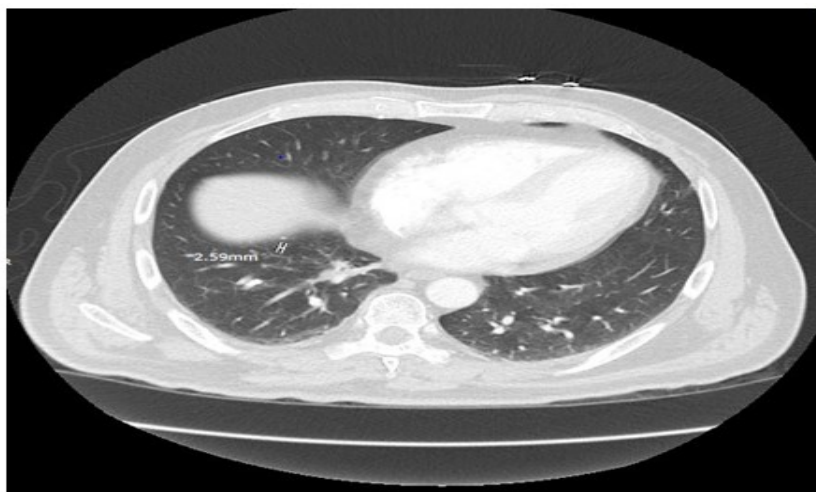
CT thorax showing a 4 mm and 3 mm pulmonary nodule at right lower lobe.
